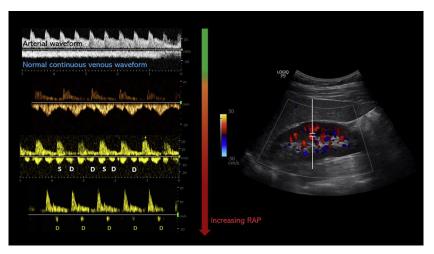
(Left panel) Transition of intrarenal venous waveform (below the baseline) with increasing right atrial pressure (RAP). The normal waveform is relatively continuous; and as the RAP increases, the flow becomes pulsatile and biphasic, with distinct systolic (S) and diastolic (D) waves. Further increases in RAP lead to a monophasic (diastolic-only) pattern, in which case the flow is entirely dependent on right ventricular filling. Arterial waveform is often displayed above the baseline, which helps in identifying the phases of cardiac cycle. (Right panel) Color Doppler image (GE Logiq) of the kidney, demonstrating the position of spectral Doppler sample volume (typically, interlobar vessels).
